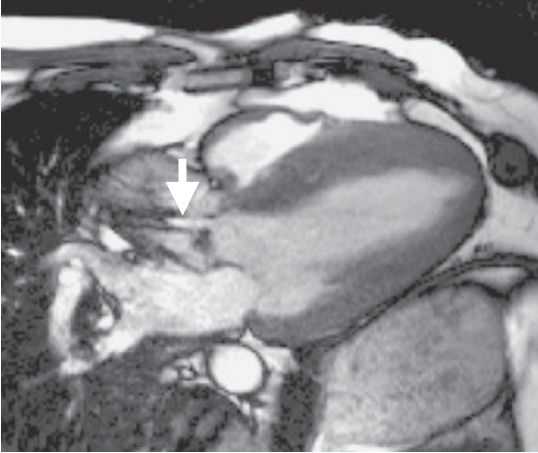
Cardiac magnetic resonance image of severe AS, demonstrating a high velocity eccentric jet of aortic flow.
